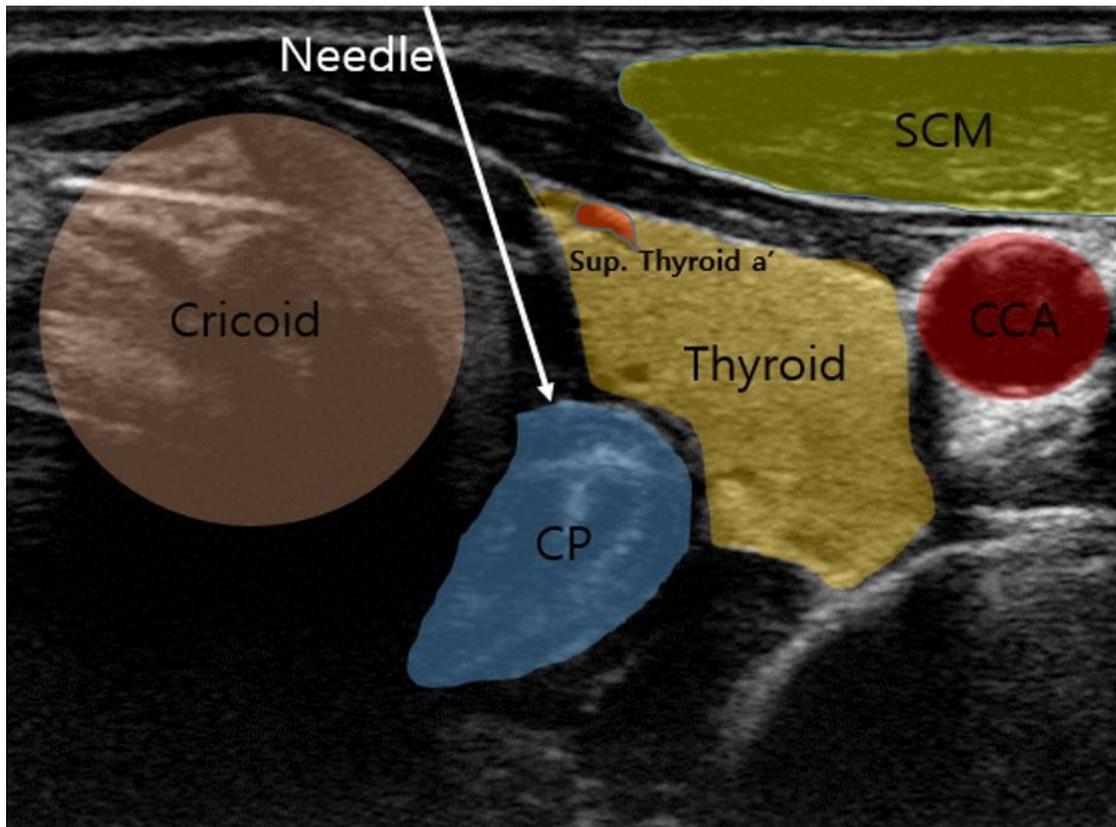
Ultrasound-guided injection to the cricopharyngeal muscle image. Axial view in right neck rotation position. The white arrow indicates the advancement course of the needle. SCM: sternocleidomastoid muscle, CCA: common carotid artery, CP: cricopharyngeal muscle.
